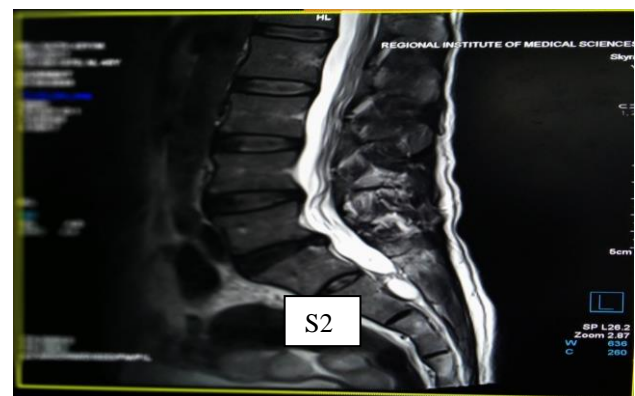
MRI LS spine sagittal view showing prolapsed intervertebral disc at L4-L5, L5-S1 level with associated finding of a single tarlov cyst in the S2 region of his spine.
